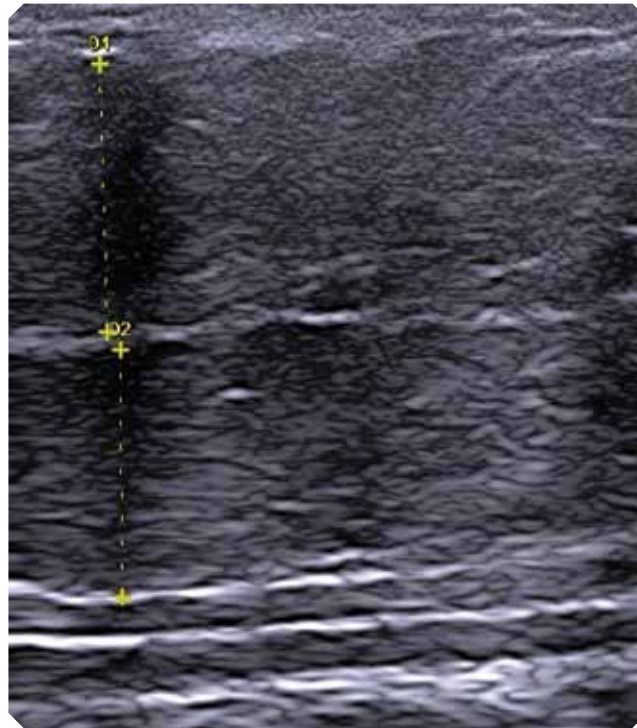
High-frequency high-resolution ultrasound of right thigh before first HERST treatment, corresponding to cellulite degree III
